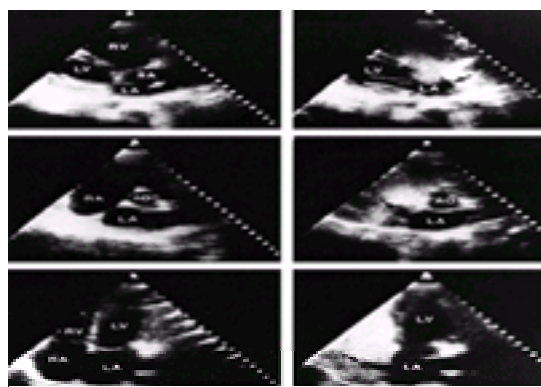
Two-dimensional echo showing right ventricular (RV) inflow tract (upper panels), short axis views at the base (middle panels) and four-chamber apical view (bottom panels) in a patient with an atrial septal defect (ASD) shown at cardiac catheterization to be associated with a Q_p/Q_s of 3.0. The left side of each panel shows the anatomy before echo contrast injection. Following an intravenous injection of agitated saline solution (right side of each panel), a negative contrast effect (*black arrows*) is seen within the right atrium (RA), compatible with entry of unopacified blood from the left atrium (LA) across the ASD into the RA. The ASD is visualized (*white arrow*) as an area of septal dropout. (Reproduced from Come PC, Riley M. Contrast echocardiography. In: Come PC, ed. *Diagnostic cardiology: noninvasive imaging techniques*. Philadelphia: JB Lippincott, 1984:294, with permission.)
